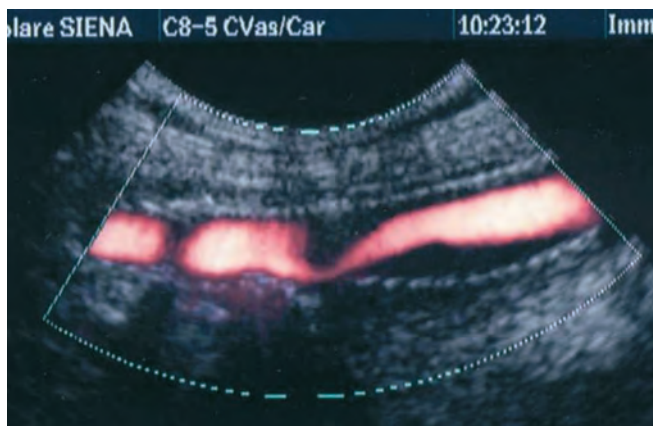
Case of ISR diagnosed by eco-color-Doppler.
